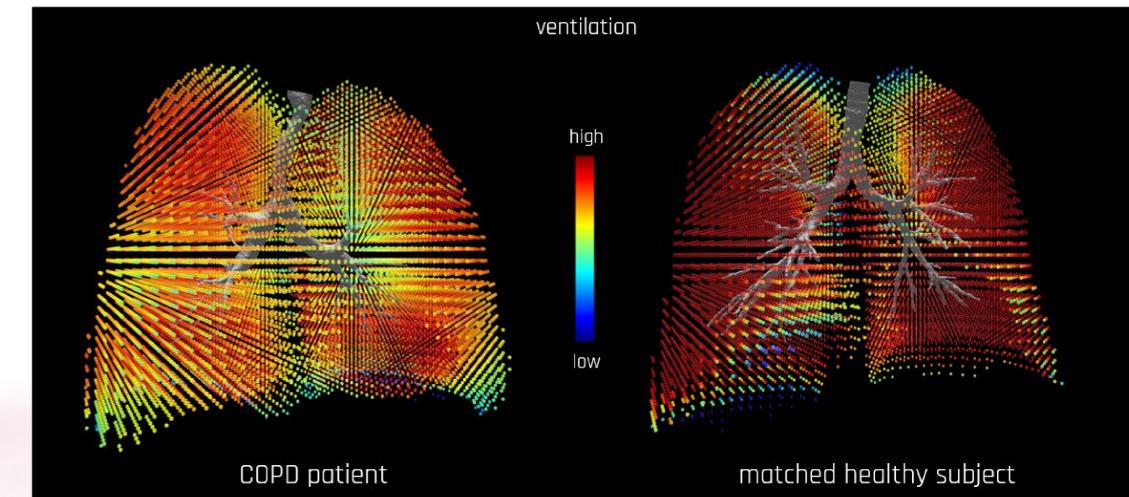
Regional ventilation map for a COPD patient and a matched healthy subject, as well as the relative effect between both. A substantial relative ventilation defect can be seen in both lung as a result of hyperinflation in COPD patients, with regional defect values up to 25%. Ventilation maps are CT-based representations of regional ventilation, derived from pulmonary CT images acquired at two different inflation levels, functional residual capacity (FRC) and total lung capacity (TLC), without the use of exogenous contrast, by assuming that regional changes in lung volume relate to regional ventilation. The Jacobian determinant of the deformation field from FRC to TLC is calculated, which measures the differential expansion of the image.
